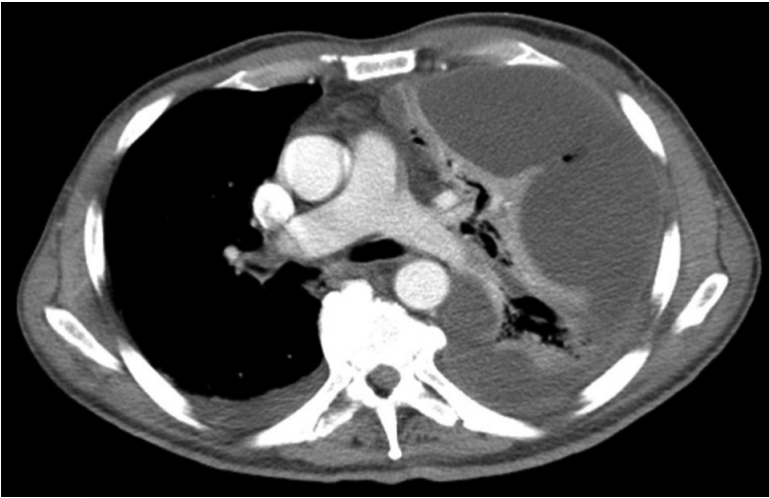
Computed tomography scan shows a multiloculated left pleural effusion
